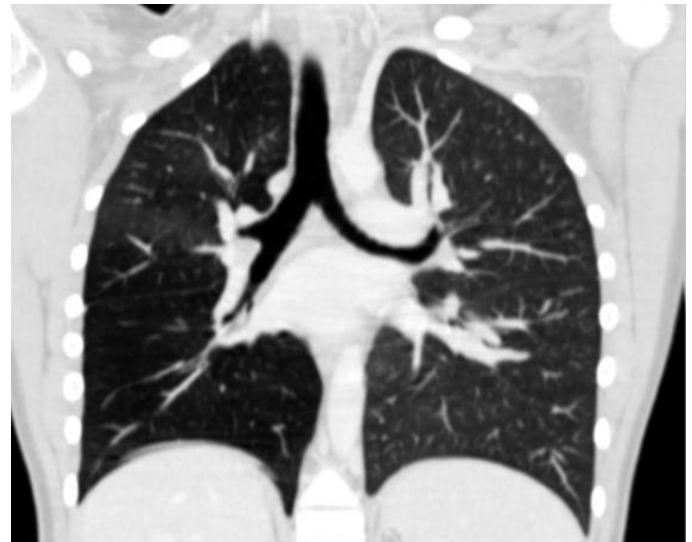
Coronal CT image with maximum intensity projection (MIP) shows right hyperlucent lung with diminished vascularity
